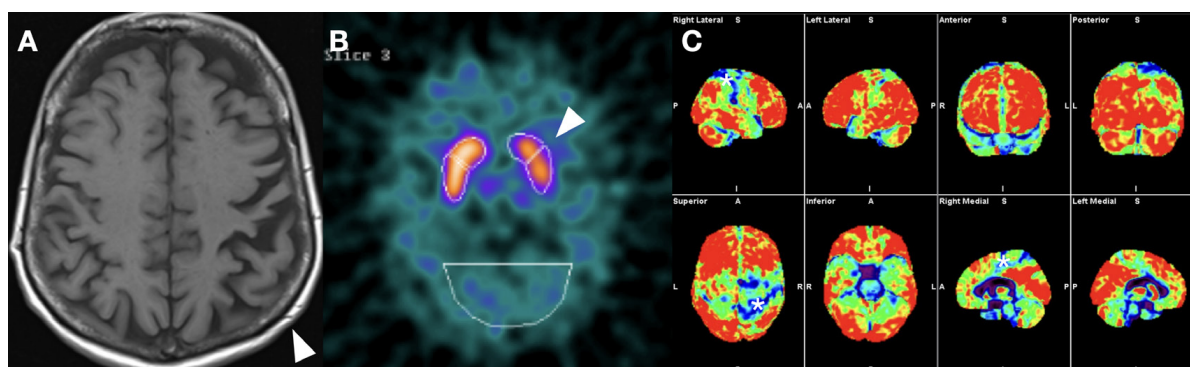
(A) Axial T1-weighted MR imaging of a patient initially reported as normal age related involuntional change, demonstrates asymmetric frontoparietal atrophy on the left side (white arrow), subsequently diagnosed with CBD. (B) 123I-Ioflupane-SPECT in the same patient, demonstrates unilateral balanced loss of radiotracer uptake within the left caudate and putamen (white arrow). (C) 18F-FDG-PET imaging in a different patient demonstrates asymmetric hypometabolism in the superior parietal and posterior frontal areas bilaterally, more pronounced on the right side (white asterisk).
